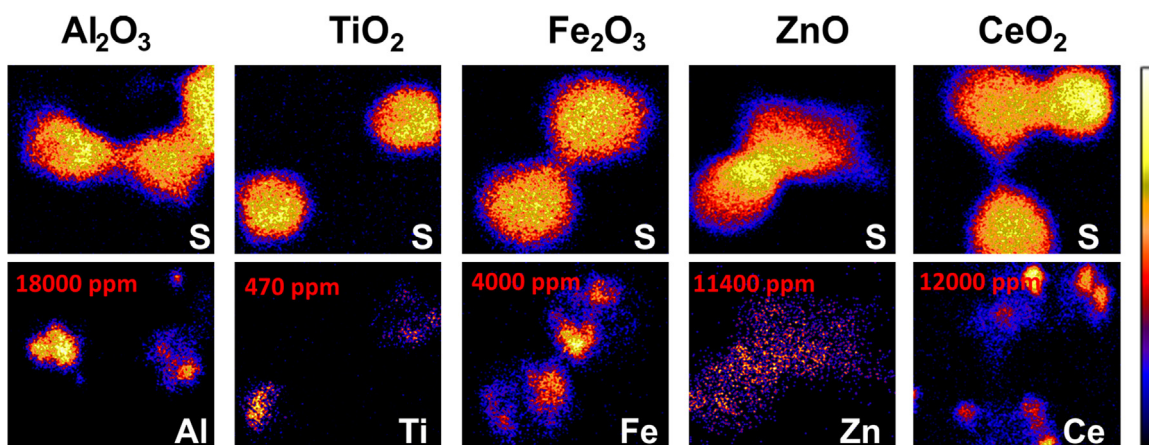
Micro-proton-induced X-ray emission (μ PIXE) elemental mapping of A549 cells exposed to different metal oxide NPs at a concentration of 30 μ g/ml for 48 h. Top and bottom images demonstrate S and NP related element distributions, respectively. The color code is as follows: yellow is the maximum, black represents the minimum. The size of all images is 50 \times 50 μ m. (Reproduced with permission from Ref. [152].) (For interpretation of the references to color in this figure legend, the reader is referred to the web version of this article.)
